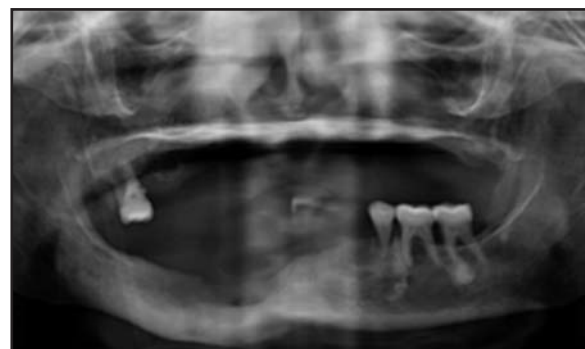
Control orthopantomography in which is seen the satisfactory development of bone re-ossification of the osteonecrosis in the mandible
